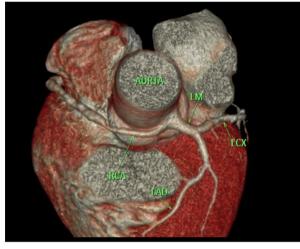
CT Angiogram showing anomalous RCA originating from left sinus with stenosis in proximal RCA.
